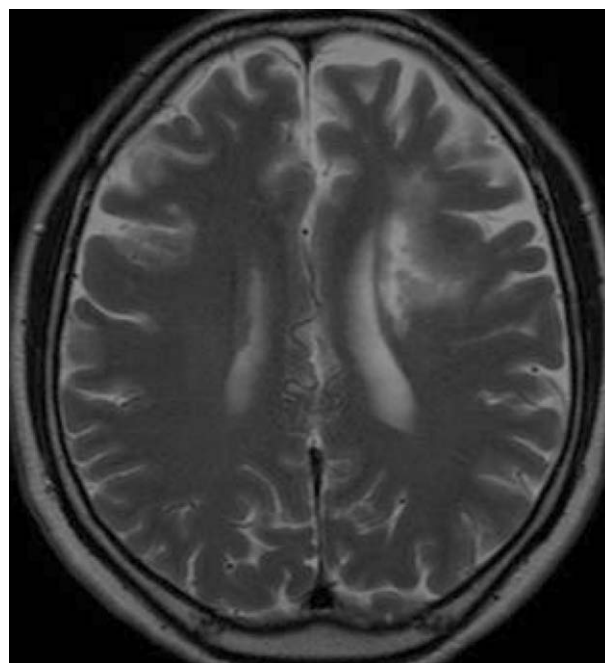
A 52-year-old woman who presented with minor completed stroke. T2-weighted MRI demonstrated an infarct in the deep white matter of the left frontal lobe
